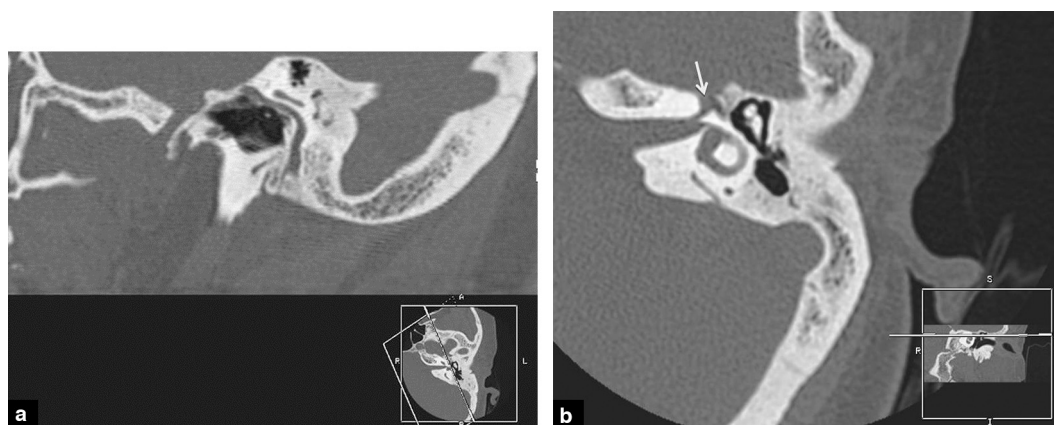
CT-scan of the petrosal bone. a: reconstruction in oblique sections revealing the tympanic and mastoid section of the facial nerve in the petrosal bone; b: axial section revealing the labyrinthine portion and the geniculate ganglion.
